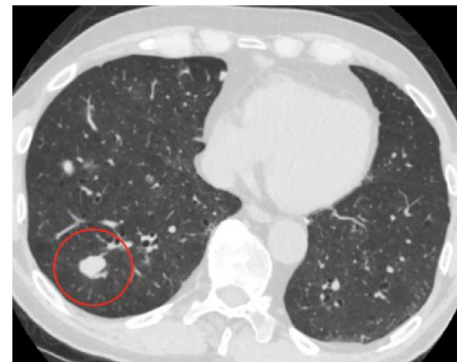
Chest CT with contrast, lung window, showing hyperdense nodular opacity in right lower lobe circled in red.
